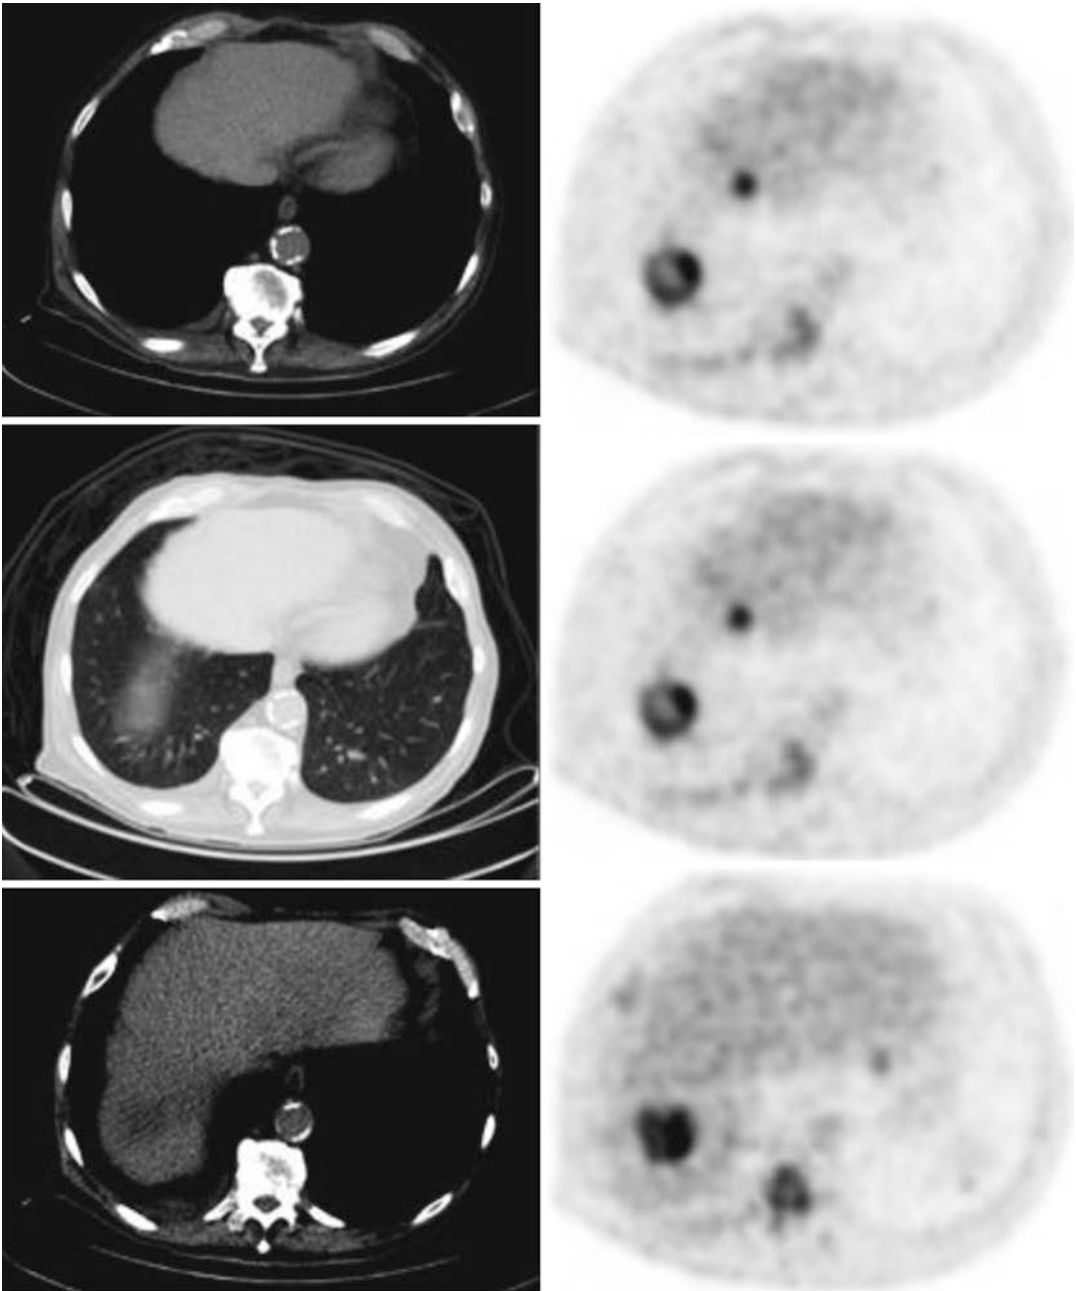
A 71-year-old male with leukemia demonstrating respiratory motion artifact. (*Top row*) Focal FDG uptake appearing in the lung base on PET image (*right*).
